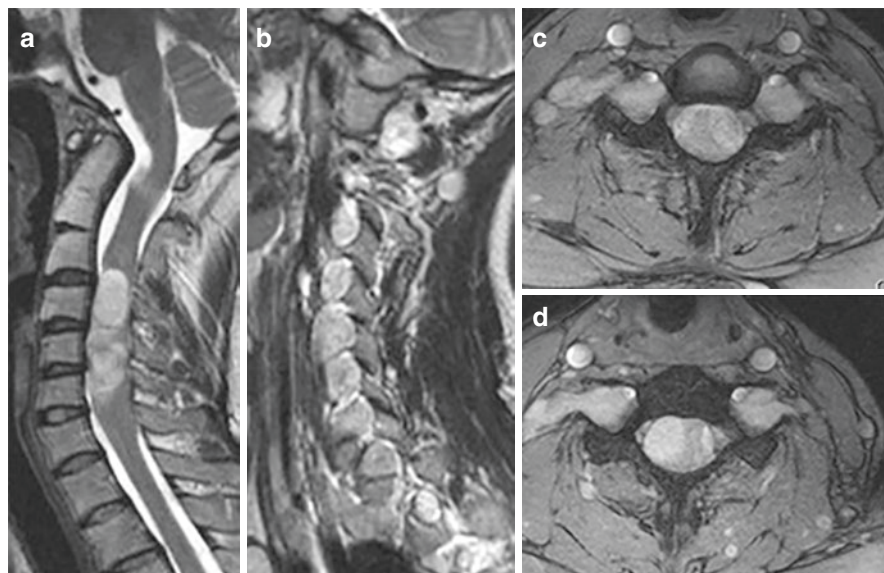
Multiple neurofibromas in 30-year-old female patient with NF1. Sagittal T2-weighted (a, b) and axial T2-weighted gradient echo (c, d) images demonstrating multiple bilateral masses
